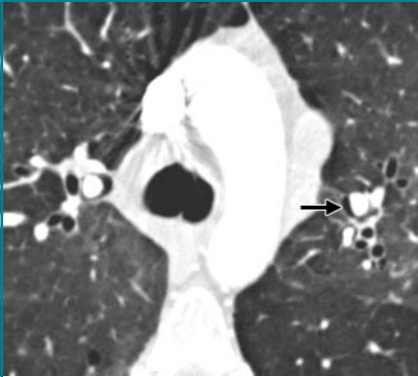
Transverse CT scan shows interstitial emphysema (arrow).
